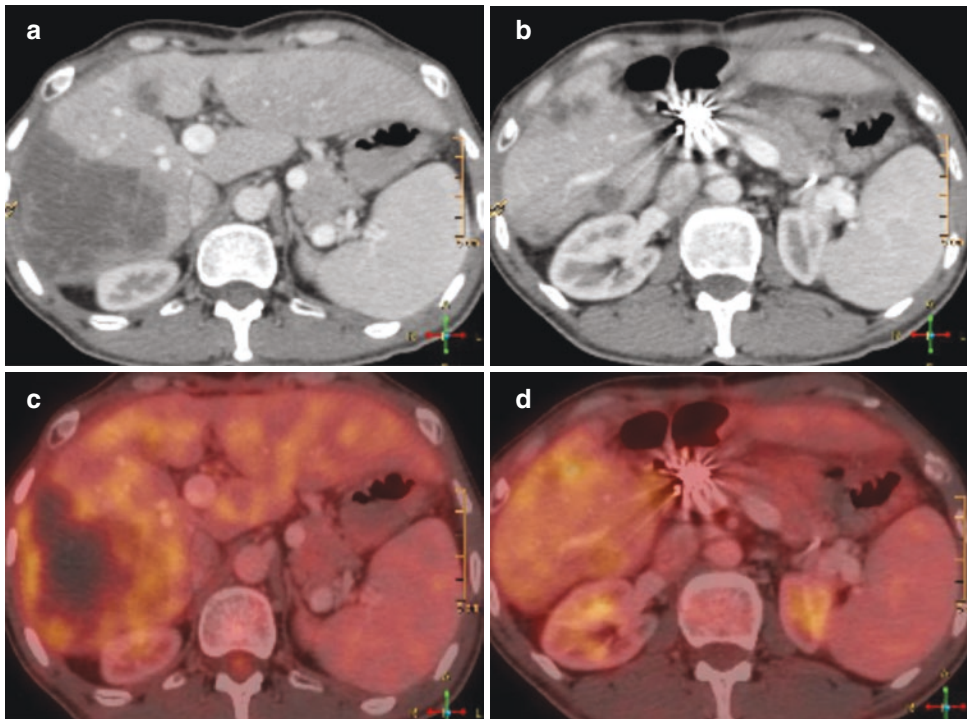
(a–d) Follow up PET- CECT, 3 months after TARE shows excellent response in the form of decreased FDG uptake
